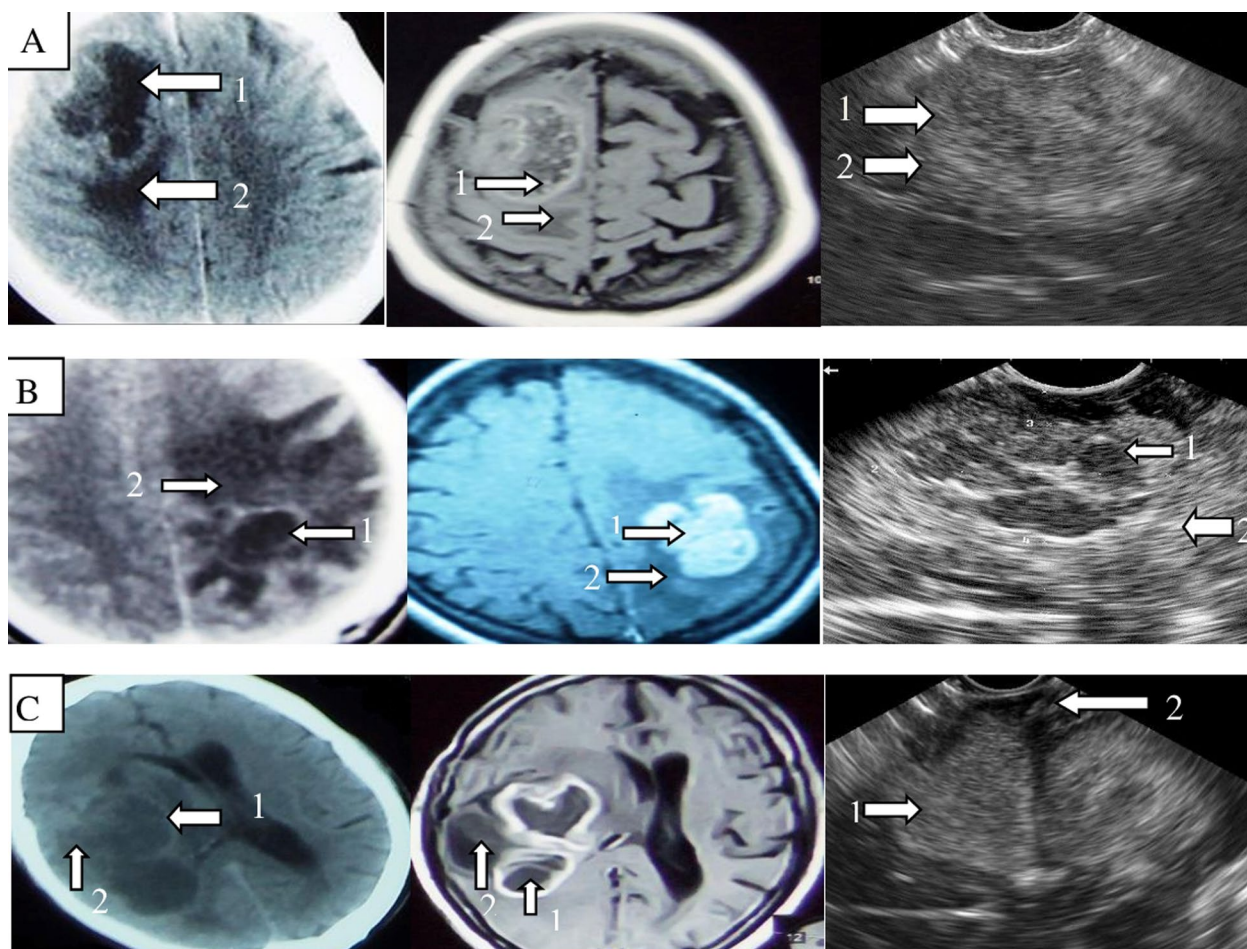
Imaging of brain metastases by CT with contrast, MRI with contrast and IOUS. Arrows 1 refer to the fleshy tumor and arrows 2 refer to brain edema. Case a: Well-defined fleshy mass with heterogeneous enhancement and central necrosis in CT and MRI. Well-defined fleshy mass with hyper-echogenic periphery and hypo-echogenic center in IOUS. Case b: Ill-defined mass with heterogeneous enhancement in CT and well defined with homogenous enhancement in MRI. Well-defined fleshy mass mostly hypo-echogenic in IOUS. Case c: Ill-defined mass with heterogeneous enhancement in CT and well defined with heterogeneous enhancement in MRI. Well-defined fleshy mass with heterogeneous hyper-echogenicity in IOUS. The ultrasound criteria of high-grades tumors as noted in these cases are irregular contours, necrosis, brain edema, hypo-echogenicity, and heterogeneity
